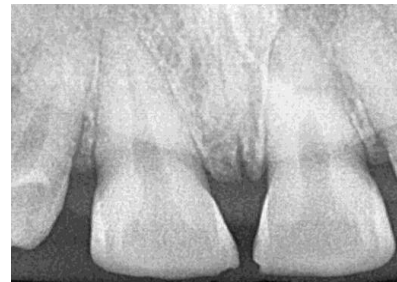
Radiograph taken after file retrieval
